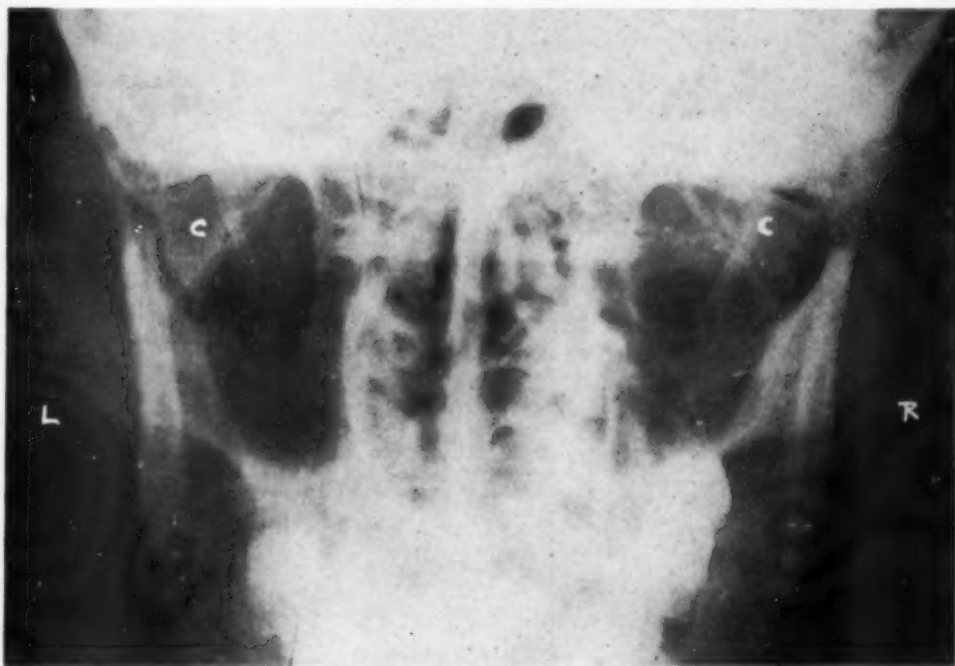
Anteroposterior x-ray showing on the left a fracture of the neck of the condyle (C) and on the right a comminuted fracture of the condyle (C) with dislocation.
